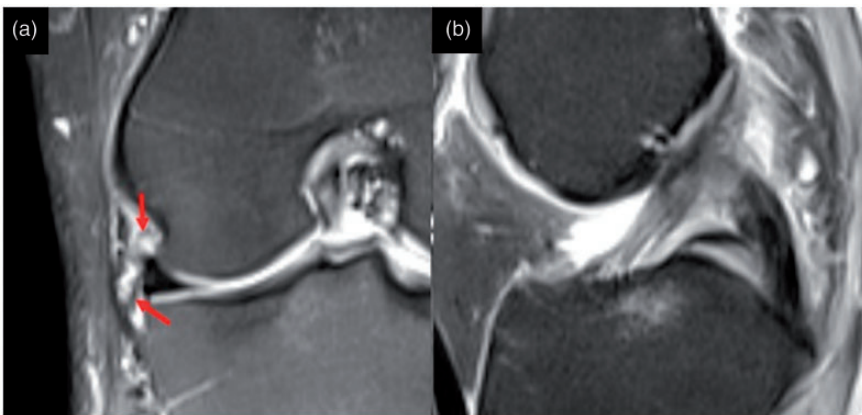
Representative fat-saturated proton density-weighted magnetic resonance images showing ligament injury. (a) In the coronal plane, the meniscal components of the anterolateral ligament were partially disrupted and torn, as shown by the red arrows. (b) The same patient's sagittal magnetic resonance images revealed a partial anterior cruciate ligament tear.
